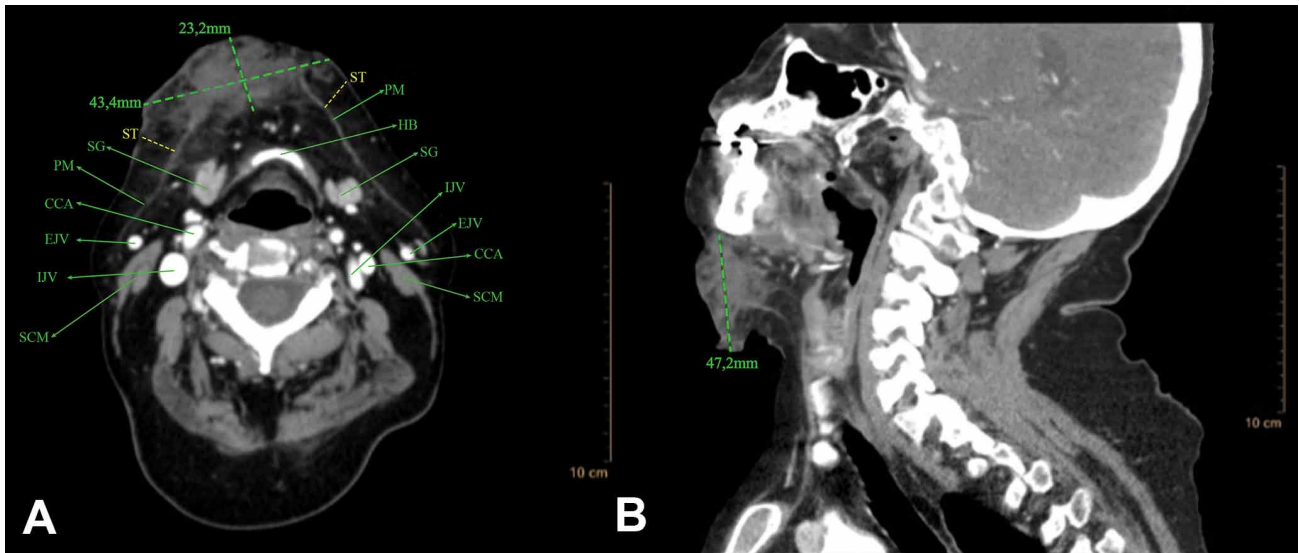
Contrast-enhanced computed tomography of the neck. A: Horizontal submandibular section shows confluent hypodense foci with slightly hyperemic areas in the submental, right submandibular, and adjacent soft tissue regions. Loss of continuity of the platysma muscle is observed. Hyoid Bone (HB), Sternocleidomastoid Muscle (SCM), Platysma Muscle (PM), Submandibular Gland (SG), External Jugular Vein (EJV), Internal Jugular Vein (IJV), Common Carotid Artery (CCA), Subcutaneous Tissue (ST). B: Parasagittal section, right side, showing a hypodense area that compromises the cortical bone and adjacent soft tissues. It extends from the lower margin of the mandible to the anterior region of the neck.
